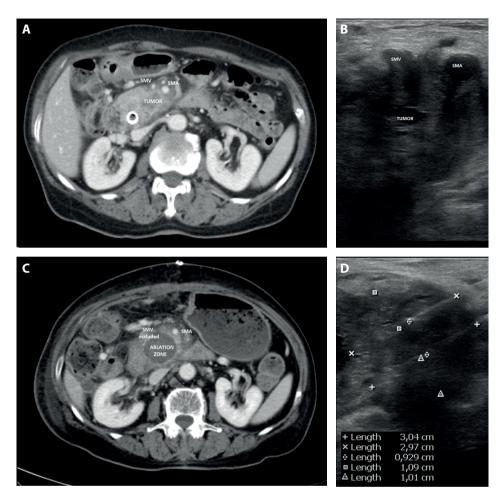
Preoperative CT-scan, intra-operative ultrasound and post-operative CT-scan in a patient with LAPC treated with RFA
